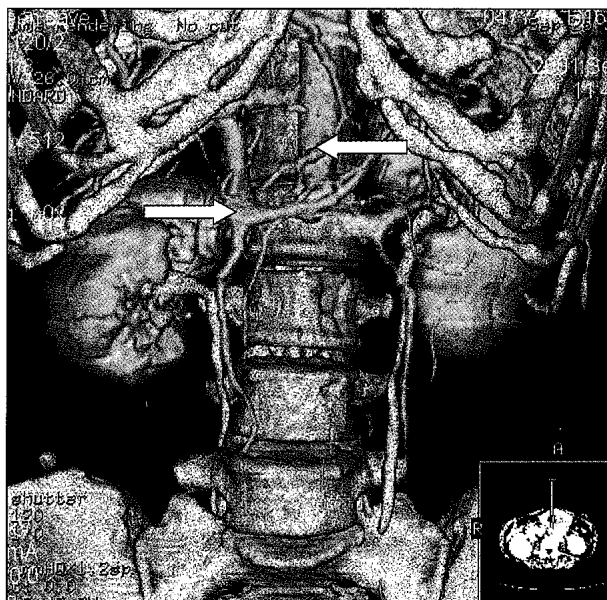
Contrast enhanced spiral computed tomography scan showed abdominal aorta inferior vena cava thrombosis
